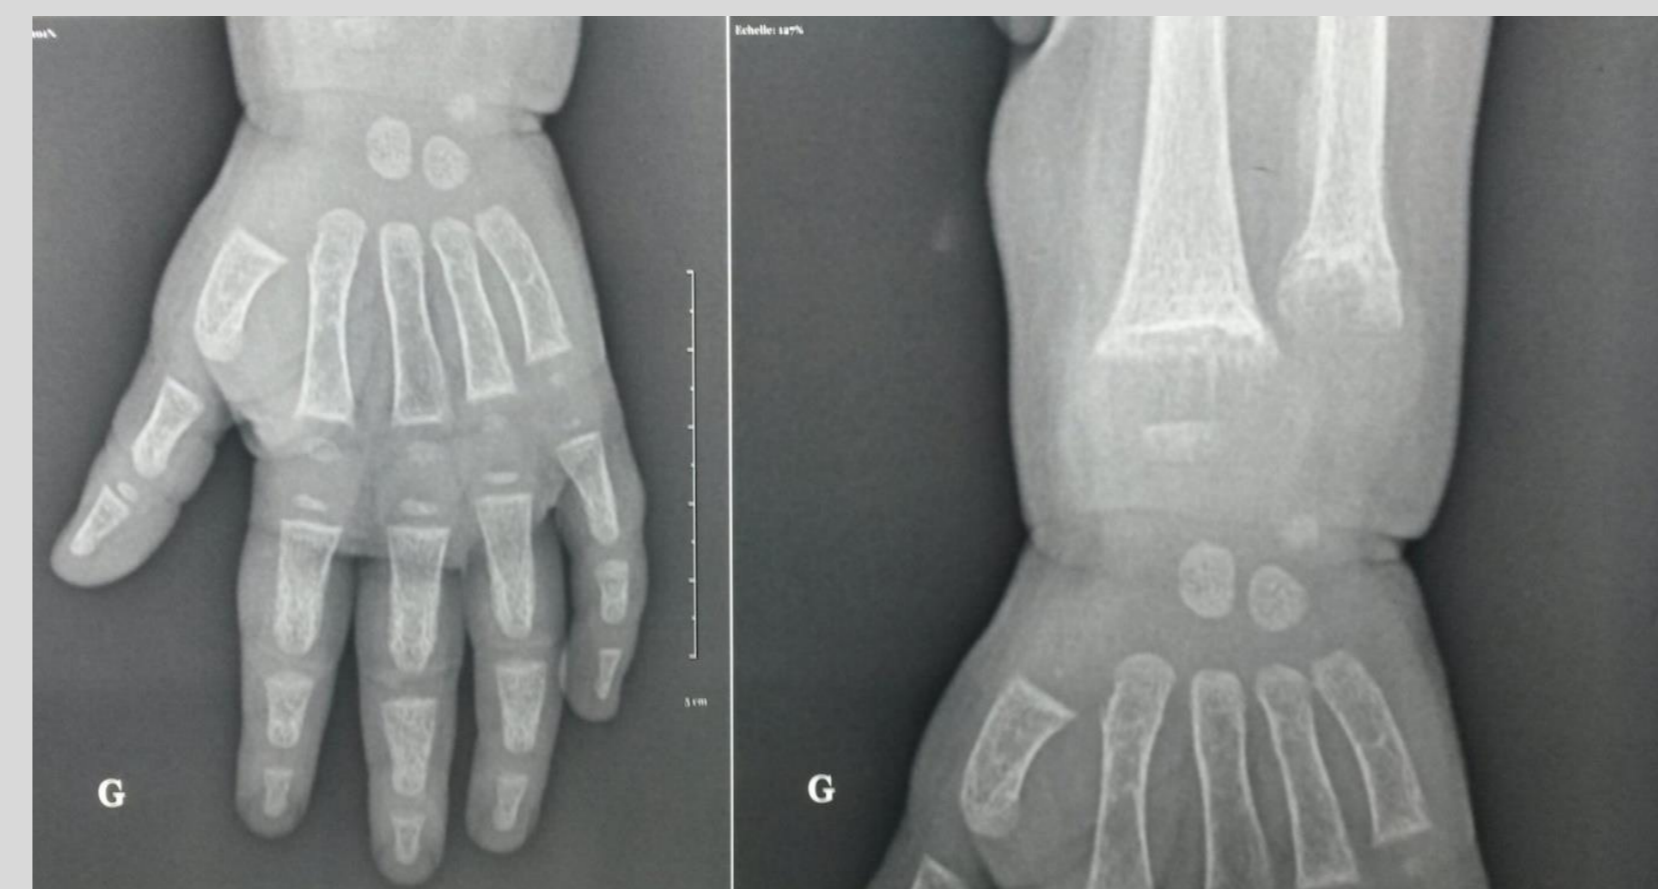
X-ray of the left wrist : cupping and flared appearance of the metaphyses.
